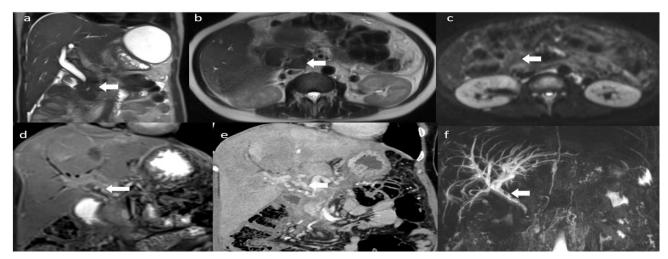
Coronal (a) and axial (b) T2-weighted images show hypointense soft tissue around the common bile duct (arrow), indicating mass-forming PB. Diffusion Weighted Imaging (c) reveals no significant diffusion restriction in the lesion (arrow). Contrast-enhanced T1-weighted image (d) and coronal reformatted Computed Tomography image (e) images show dilated collateral veins (arrow) along the common bile duct and central intrahepatic duct dilation. Follow-up Magnetic Resonance Cholangiopancreatography image (f) shows gallstones (arrow) in the common bile duct.
